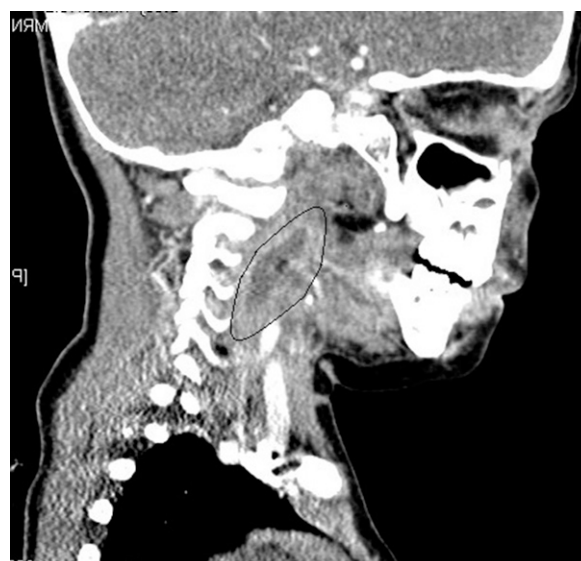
Contrast sagittal computed tomographic image demonstrating a retropharyngeal abscess (circled).
